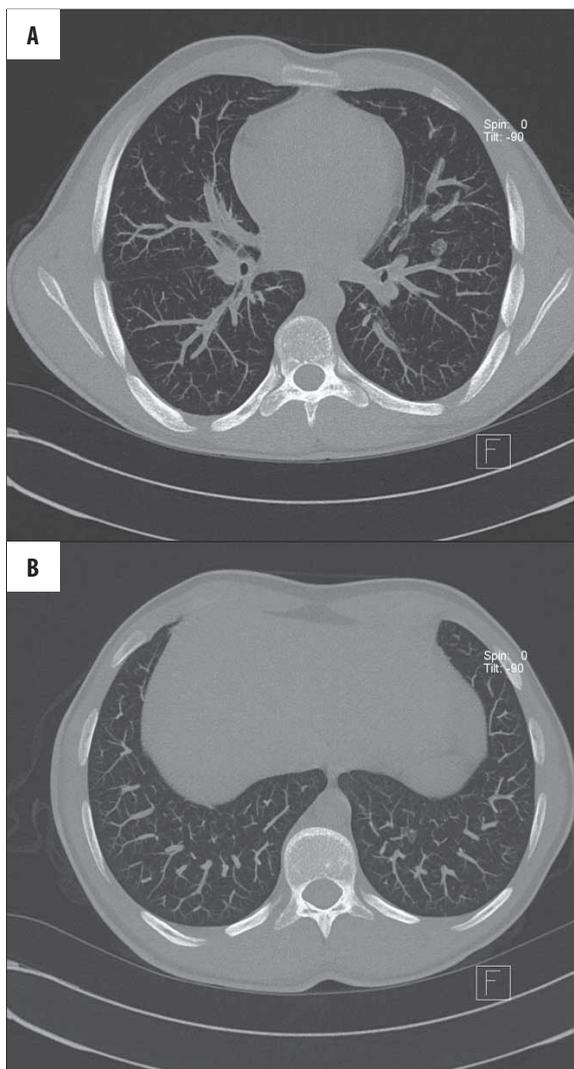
Figure 4AB. Chest CT – two solid lesions visible.
